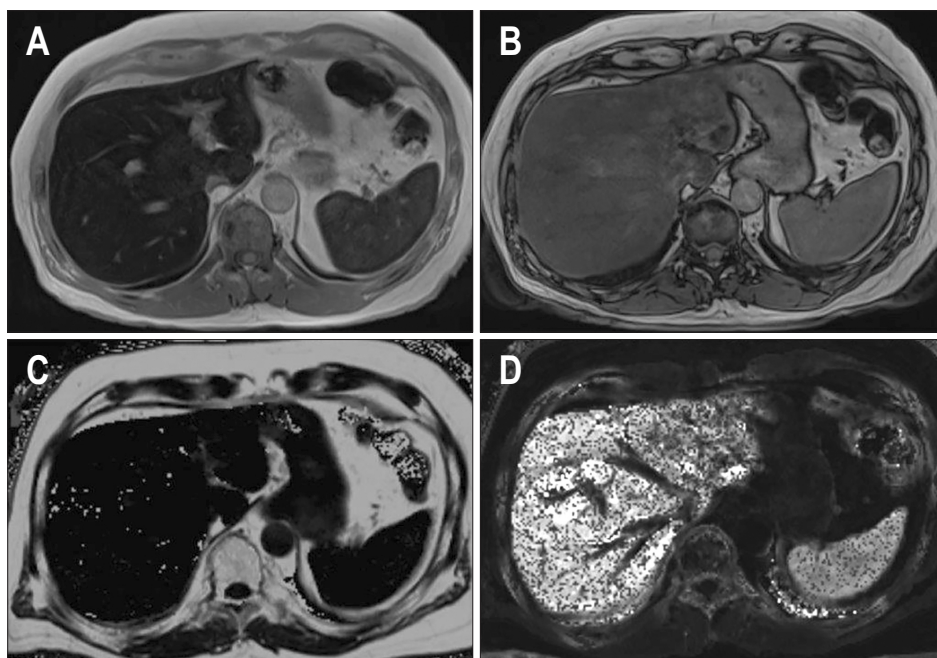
Chemical shift encoded magnetic resonance images of a patient with hemosiderosis and severe iron overload in the liver and spleen. In-phase (A) and out-of-phase (B) images show loss of signal in the liver on in-phase images compared to the out-of-phase images suggesting iron overload. Corrected proton density fat fraction (C) and $R2^*$ maps (D) are shown at the bottom. Increased pixel intensity on the $R2^*$ map suggests iron overload. The patient had a mean $R2^*$ value of 683 s^{-1} equivalent to liver iron concentration of 9.91 mg Fe/g .
